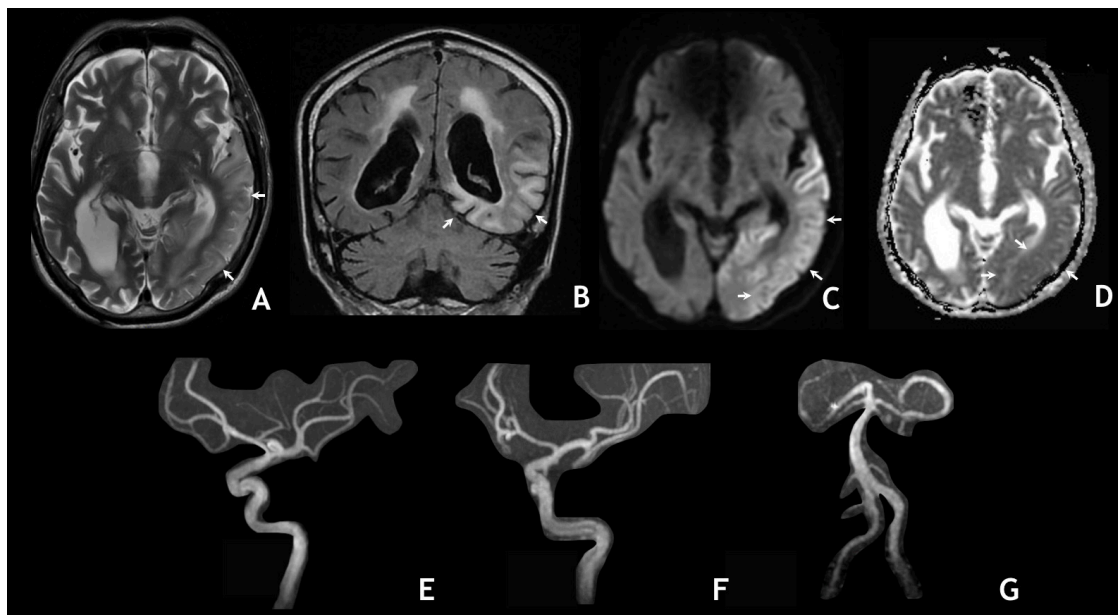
Magnetic resonance images of the brain. (A and B) Axial T2-weighted and coronal fluid attenuated inversion recovery images, respectively, confirmed the presence of cortical and subcortical white matter hyperintensities (white arrows) in the left occipital and temporal lobes that encompassed the left middle cerebral artery and posterior cerebral artery. (C and D) Axial diffusion-weighted images showed gyriform pattern of increased signal (white arrows) with corresponding low signal on apparent diffusion coefficient map which is in keeping with diffusion restriction. (E to G) Three-dimensional time-of-flight images of the right internal carotid artery, left internal carotid artery and vertebrobasilar artery, respectively, demonstrate normal flow signal.
